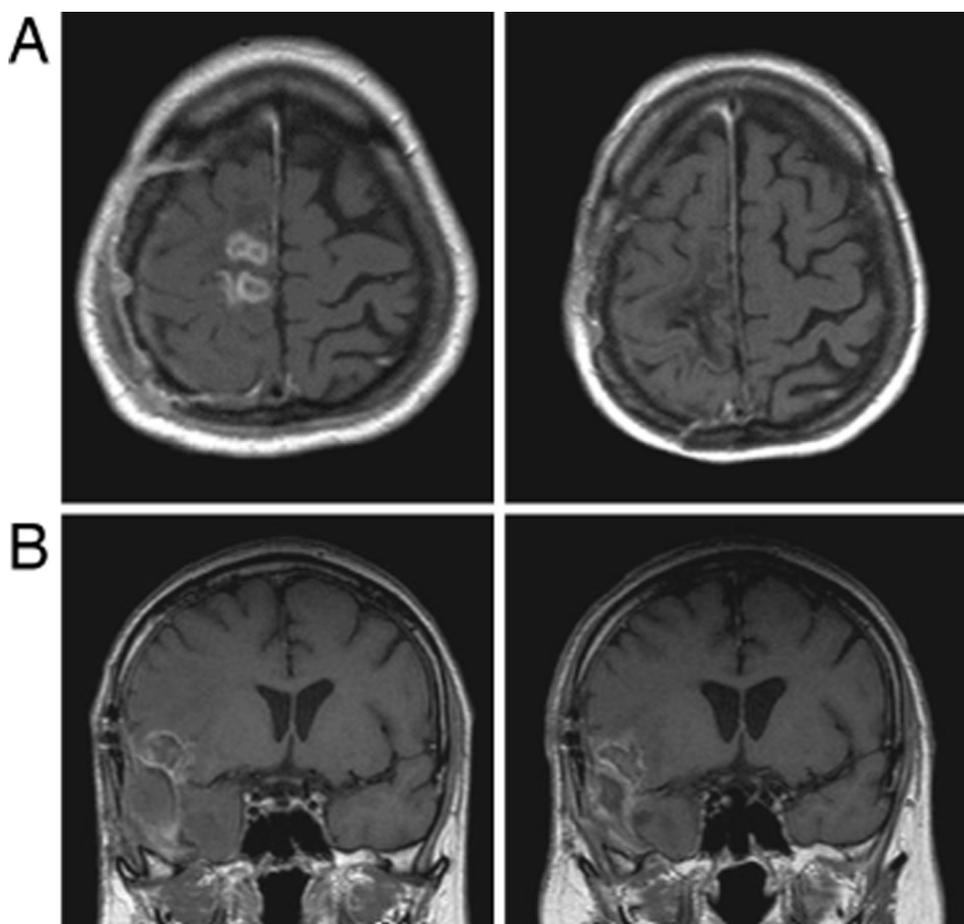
Examples of T1-weighted, post-contrast MRI scans of recurrent GBM patients before (left) and after (right) TTFIELDS treatment. A, Complete response after 8 months of treatment. B, Stable disease (10% reduction in the contrast-enhanced area) after 9 months of treatment. Adapted from Kirson, E.D., et al. (26). Copyright (2007) National Academy of Sciences.
